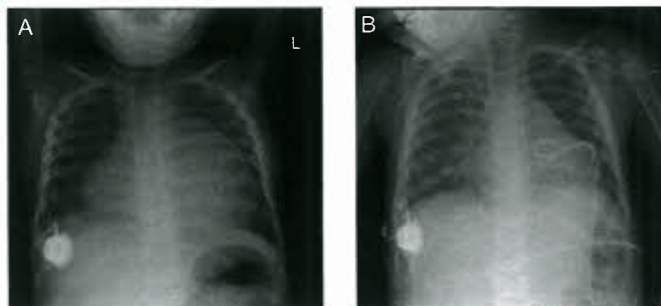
A: Chest radiograph of a 2-year-old girl who presented with tachypnea. The patient required an emergent pericardiocentesis, after which (B) her cardiothymic silhouette had markedly decreased in size.
